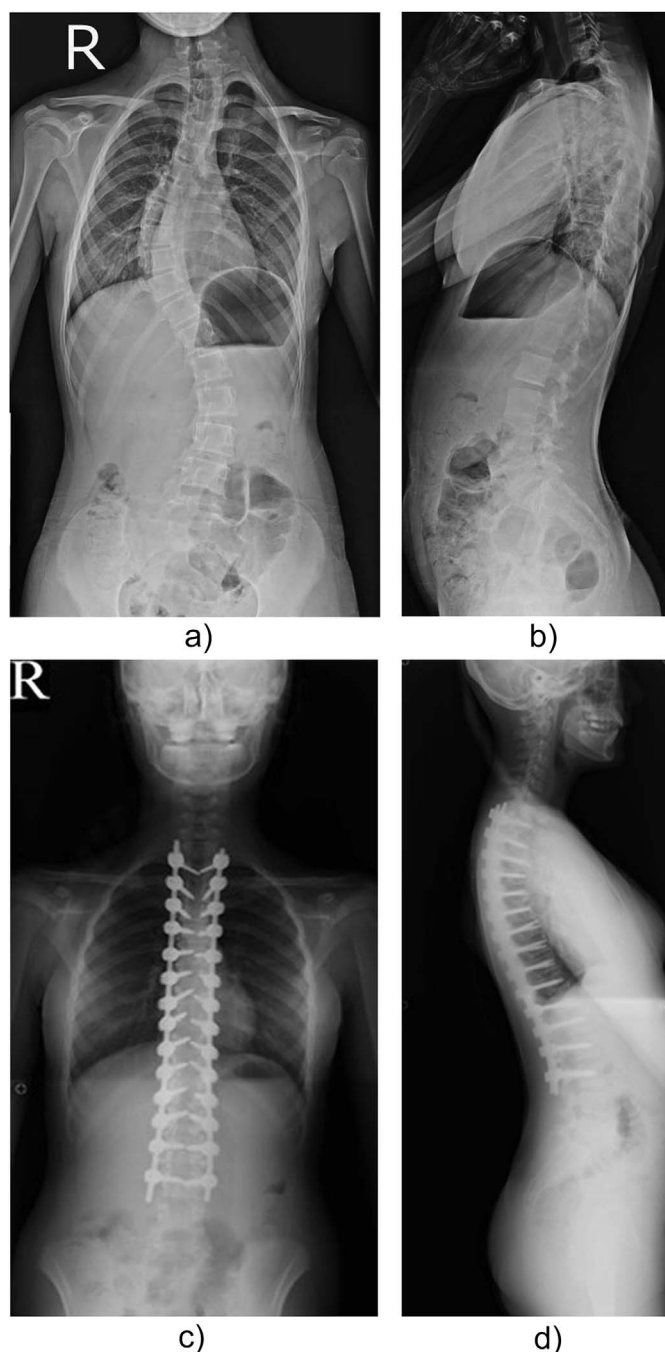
a–d: Preoperative and postoperative anterior-posterior (A–P) and lateral radiographs.
